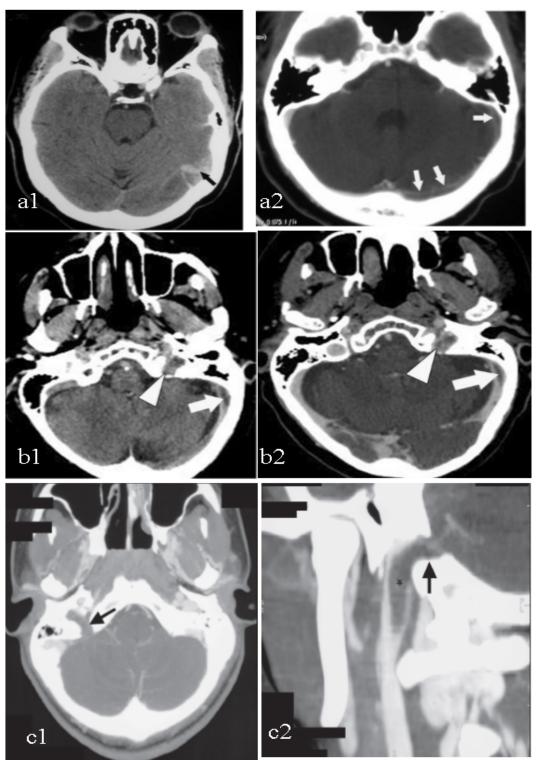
a1. Thrombosis of the left transverse and sigmoid sinuses and temporooccipital veins in a 47year-old woman. Axial unenhanced CT image showing superficial temporooccipital areas of high attenuation. Findings suggestive of thrombosed cortical veins (cord sign). a2. Axial contrast-enhanced CT image shows thrombosis of the left transverse and sigmoid sinuses. b1. Thrombosis of the left sigmoid sinus and jugular foramen in a 61-year old woman. Axial unenhanced CT image shows low attenuation in the left sigmoid sinus (arrow) and jugular foramen (arrowhead). b2. Axial contrast-enhanced CT image shows thrombi in the left sigmoid sinus (arrow) and jugular foramen (arrowhead). c1. 12-year-old girl with Internal Jugular Vein and sigmoid sinus thrombosis. Axial source image from CT venography. Thrombus in sigmoid sinus (black arrow). c2. Sagittal planar reconstruction of CT venography shows thrombus extending from right IJV (asterisk) into sigmoid sinus (arrow).
